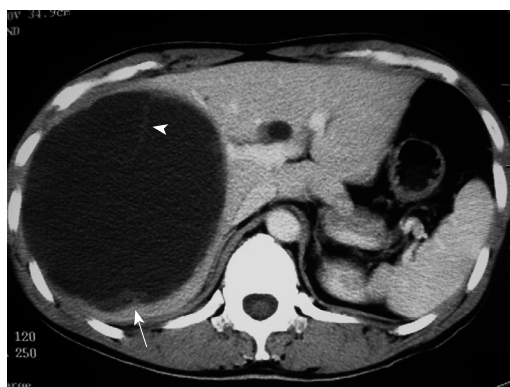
CT scan showing a huge low density cystic lesion in the right liver with high density straps (arrowhead) inside and mural nodules (arrow) on the cyst wall.
